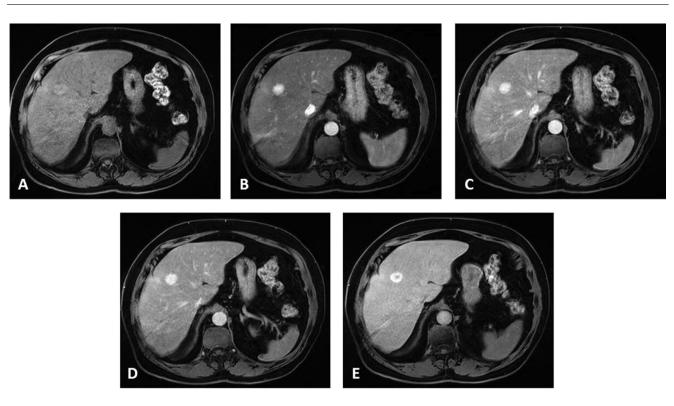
Gd-EOB-DTPA-enhanced MRI confirmed the contrastographic behavior of CT scan and revealed hyperintensity of the lesion on hepatobiliary phase image with central small hypointensity due to a central scar. The nodule in segment VII showed the some contrastographic behavior.
